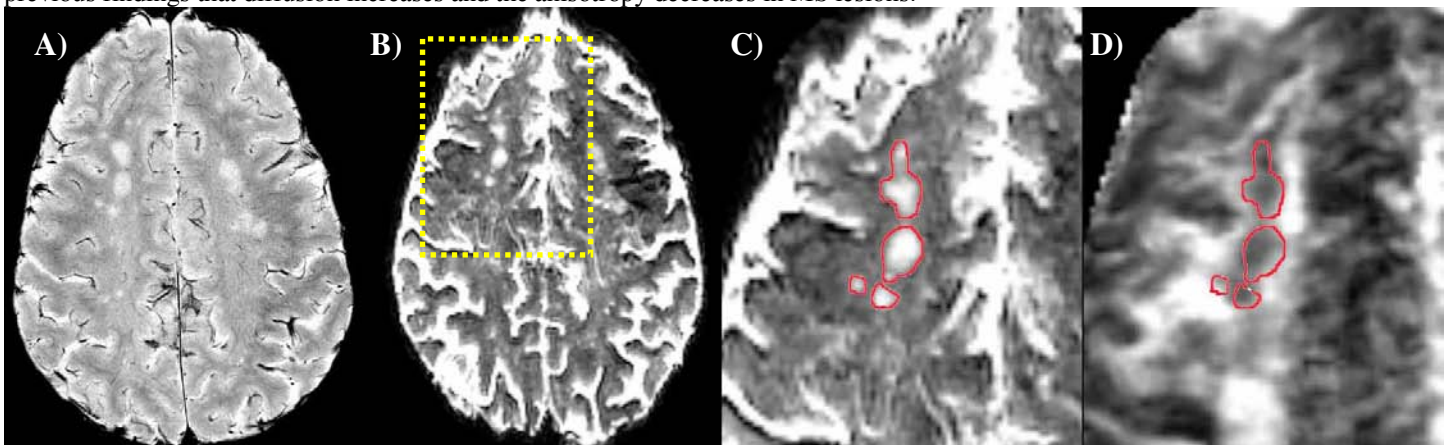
A) High resolution (215x286 μ m in-plane, 2mm slice thickness) T2* weighted image with visible white matter lesions. B) T2-weighted b=0 image from the diffusion acquisition. C) Enlarged ADC map from region indicated in (B). D) Enlarged RA map from region indicated in (B).
